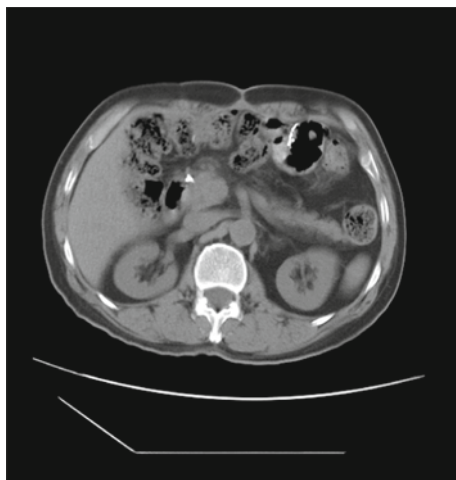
Another CT abdomen image
